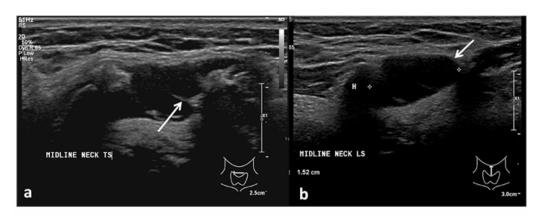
Transverse (a) and longitudinal (b) Ultrasound images of a 58-year-old female show an encapsulated cystic structure with internal septation and echogenic debris in the midline of the anterior neck. This is consistent with a thyroglossal duct cyst (arrows).
